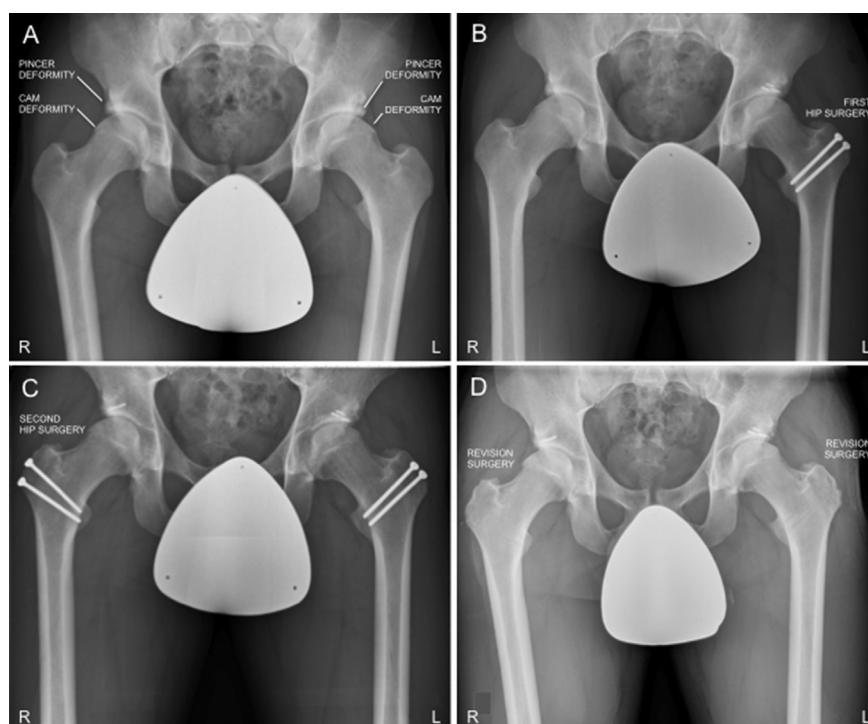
Radiographic images of both hips preoperatively (A), after first open hip surgery (B), after second open hip surgery (C), and after bilateral revision surgeries (D). R, right; L, left.
